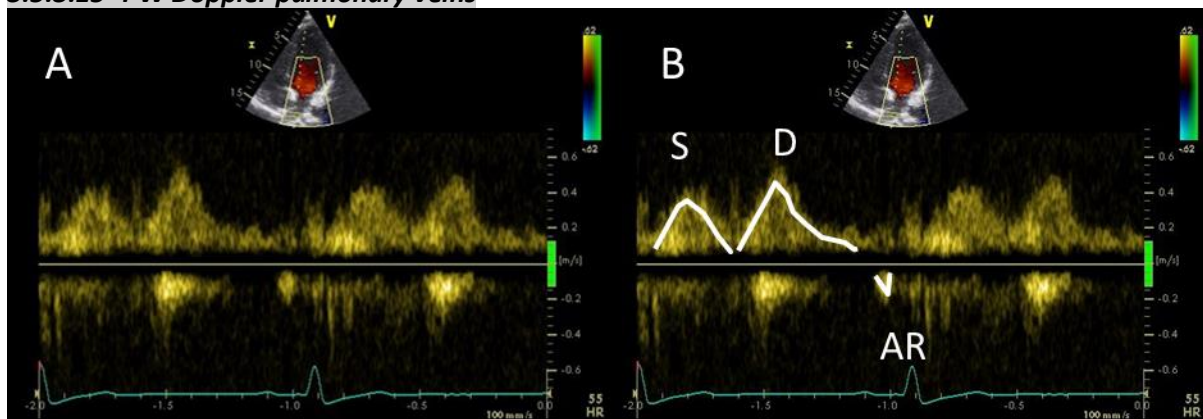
PW Doppler pulmonary veins (A) and measurement PW Doppler pulmonary veins (B)
